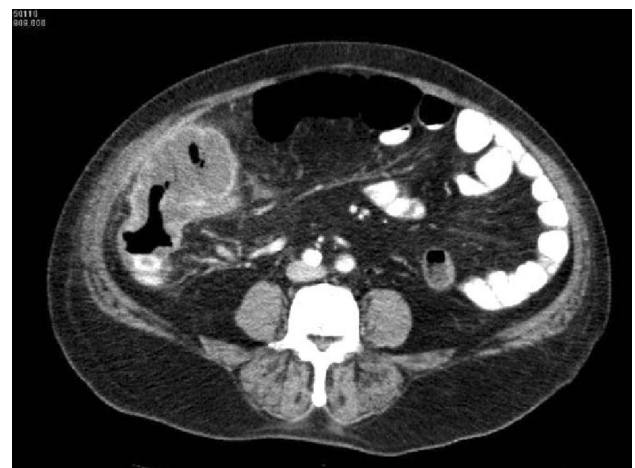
This CT image shows a cecal and ascending colon adenocarcinoma with partial luminal obstruction.
